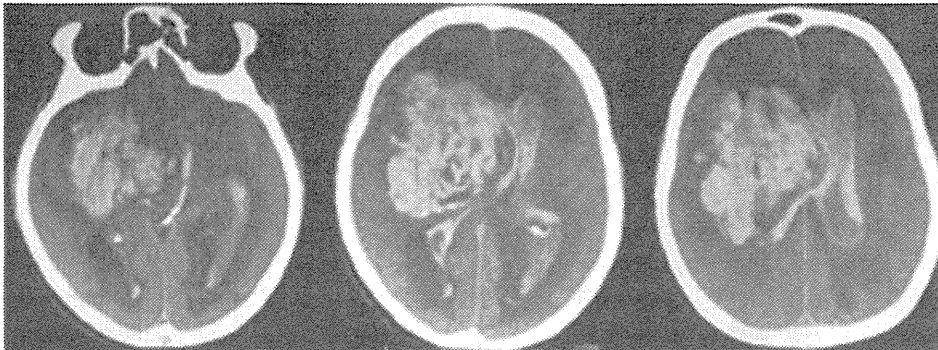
ワルファリン療法中に発症した脳内出血例の頭部 CT 写真
